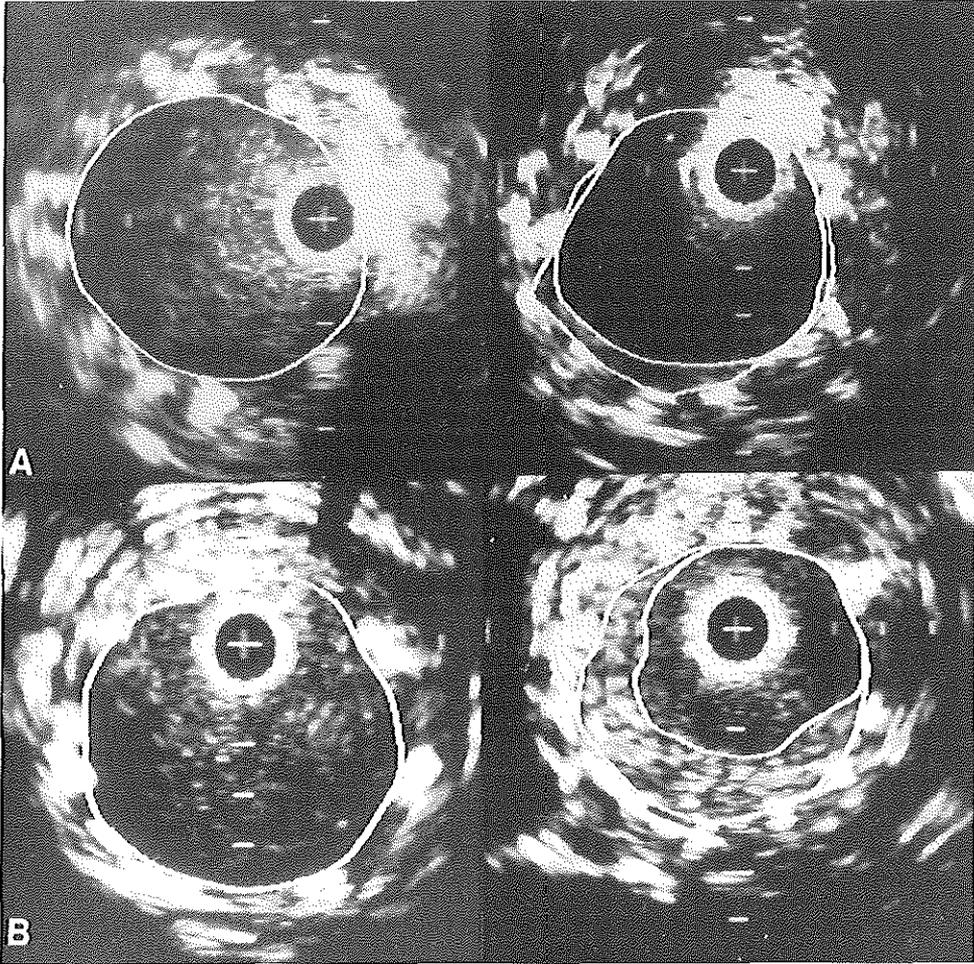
Intravascular ultrasound cross-sections after stent implantation (left panel) and at follow-up (right panel) of the renal artery (A) and femoropopliteal artery (B). Lumen area (inner contour) and stent area (outer contour) display quantitative results. A, late lumen loss is minimal and solely due to neointimal tissue proliferation. B, both neointimal tissue proliferation and stent area reduction contribute to late lumen loss at follow-up.
